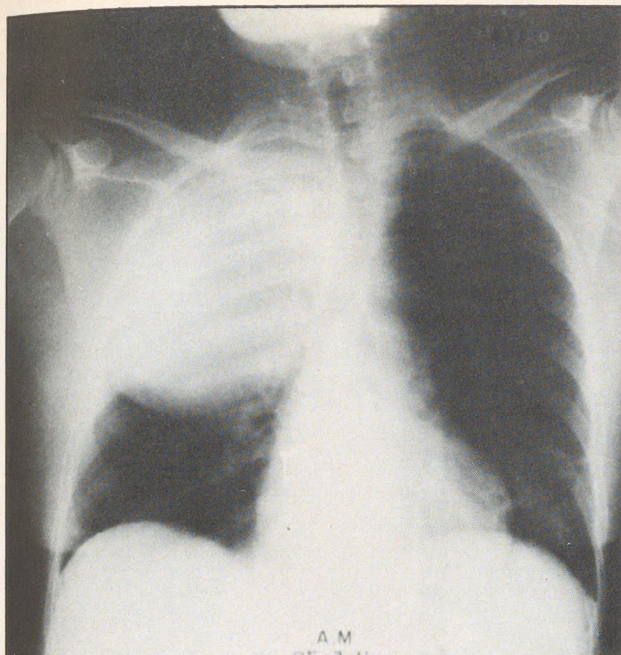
A dense infiltrate with bulging of the minor fissure is noted in this chest radiograph of a patient with acute *Klebsiella* pneumonia involving the right upper lobe.
